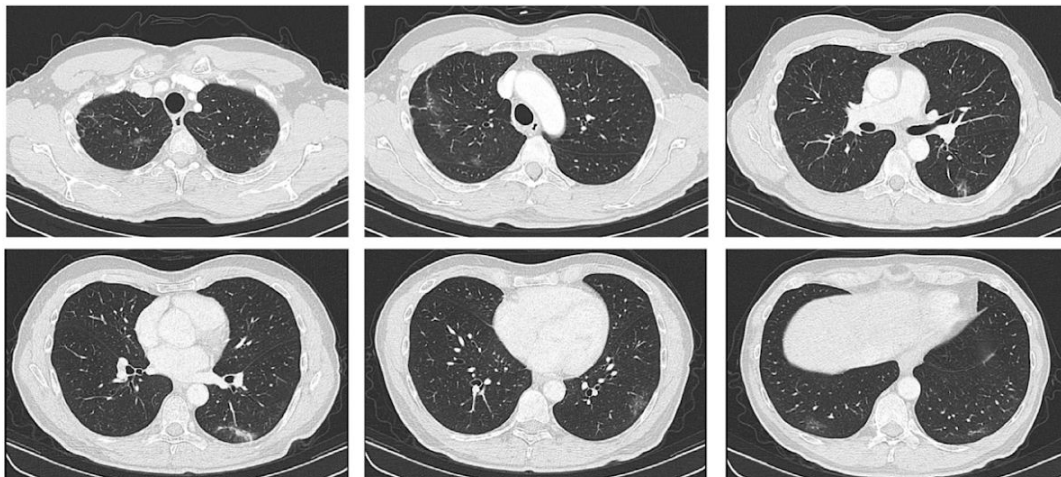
CT scan of Case 1 (alectinib for ALK-positive NSCLC) showed the onset of multiple bilateral subpleural ground glass opacities in upper and lower lobes, suspicious for SARS-CoV-2 pneumonia.
